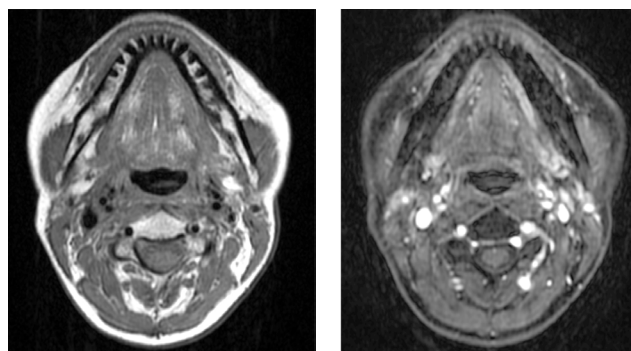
Magnetic resonance imaging after CCRT shows complete response of primary tumour and metastatic lymphnode
